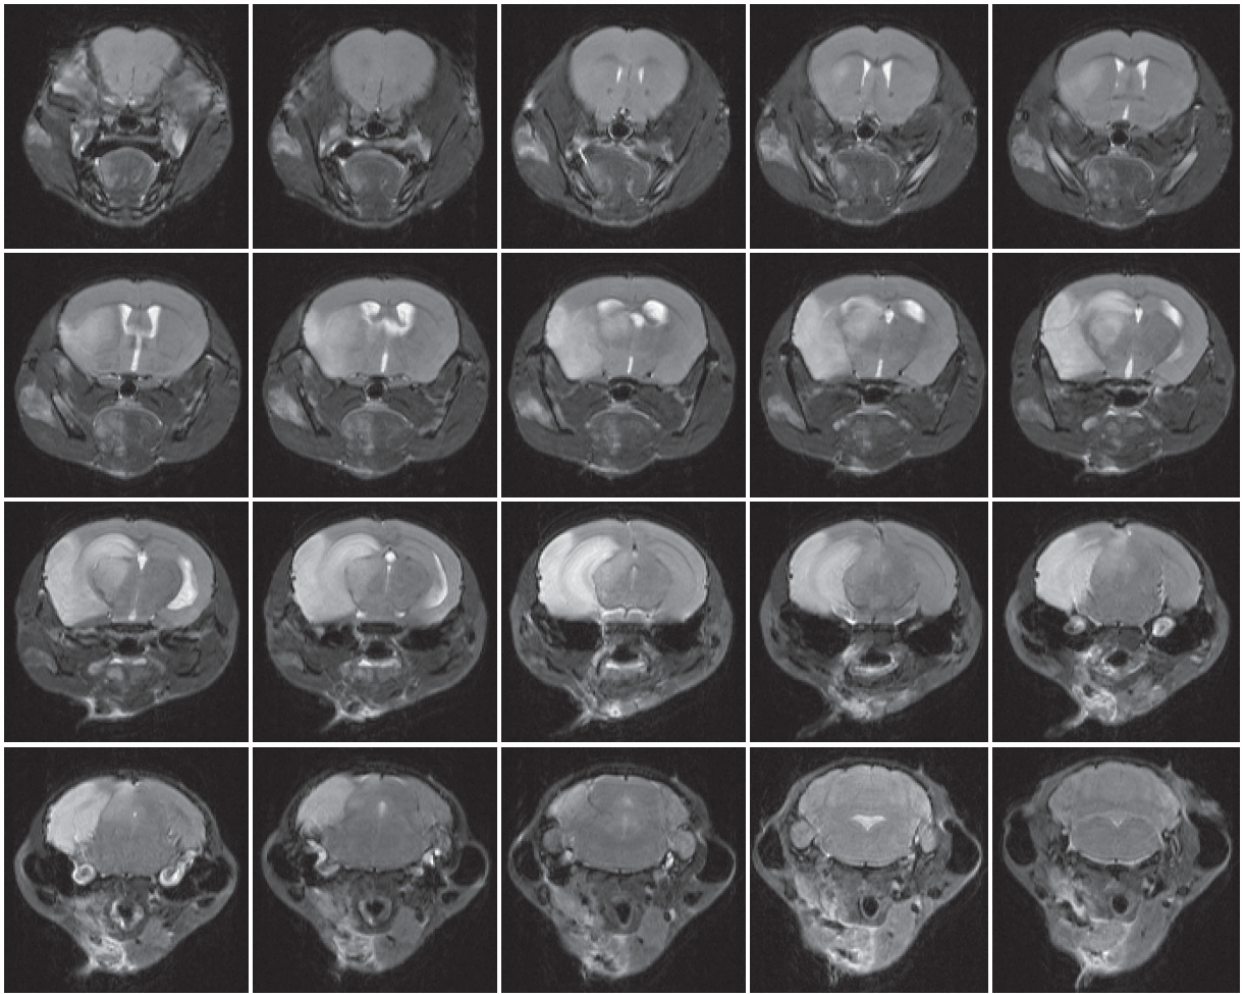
5 Infarct volumetry by MRI
